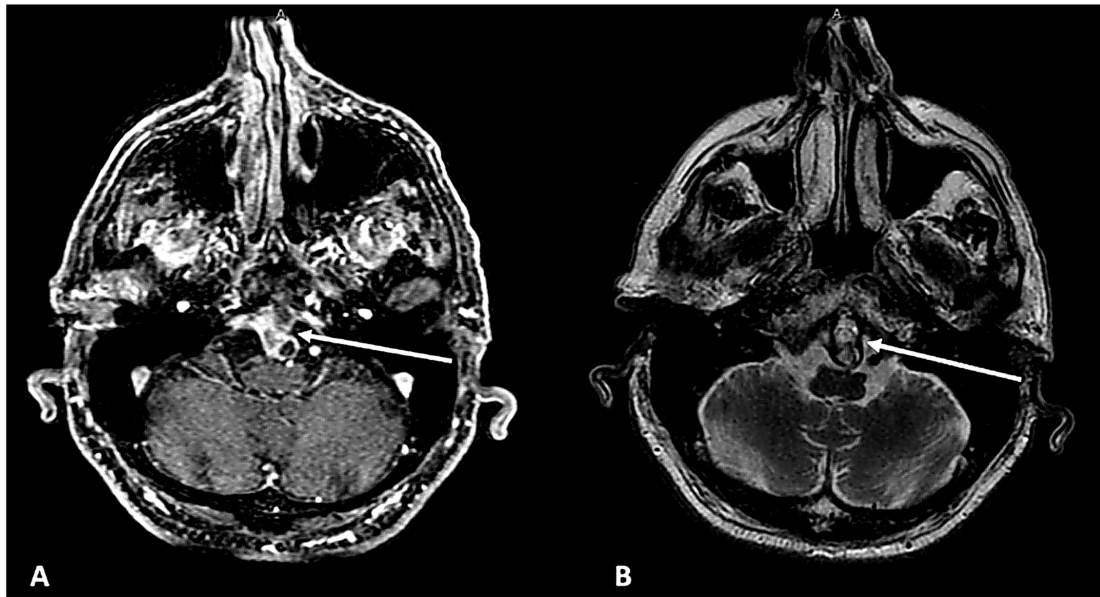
Ecchordosis physaliphora involving the clival region. (A) Axial contrast-enhanced T1-weighted MRI (T1+C) demonstrates a small, well-defined retroclival lesion without significant contrast enhancement. The arrow indicates the retroclival lesion projecting into the prepontine cistern. (B) Axial T2-weighted MRI demonstrates a markedly hyperintense lesion with cystic-like signal similar to cerebrospinal fluid. The arrow indicates the lesion abutting the ventral surface of the pons without significant mass effect. (Personal archive; patient informed consent was obtained.)
